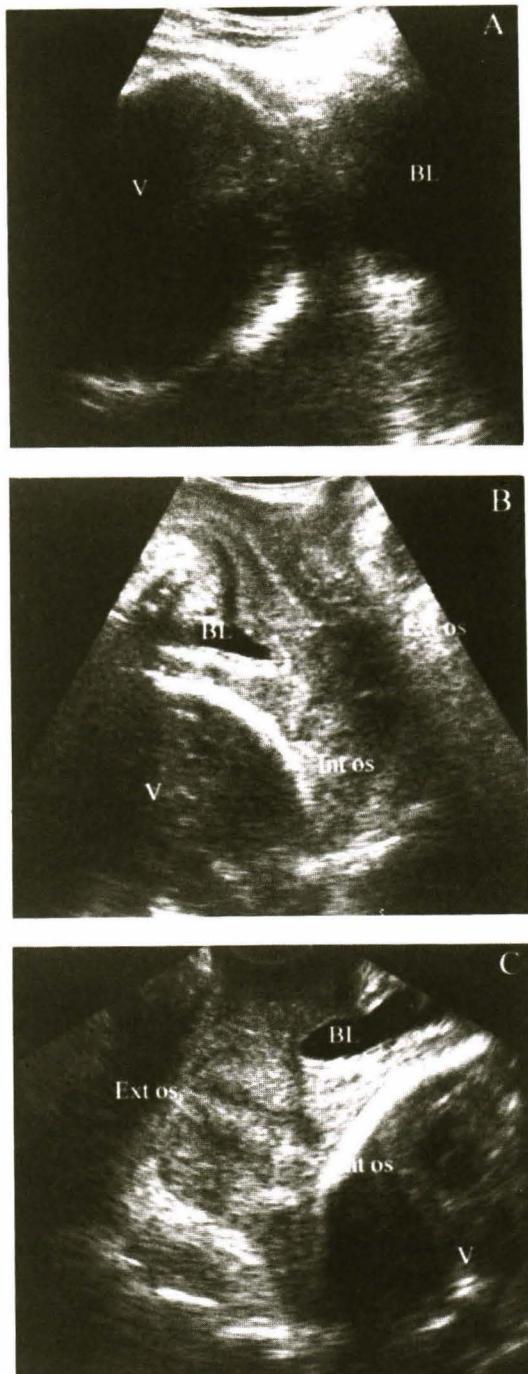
Uterine cervical ultrasonography from the same case that was visualized inadequately by transabdominal ultrasonography A), but visualized adequately by transperineal B) and transvaginal ultrasonography C). (V = vertex, BL = bladder, Ext os = external os, Int os = internal os)
